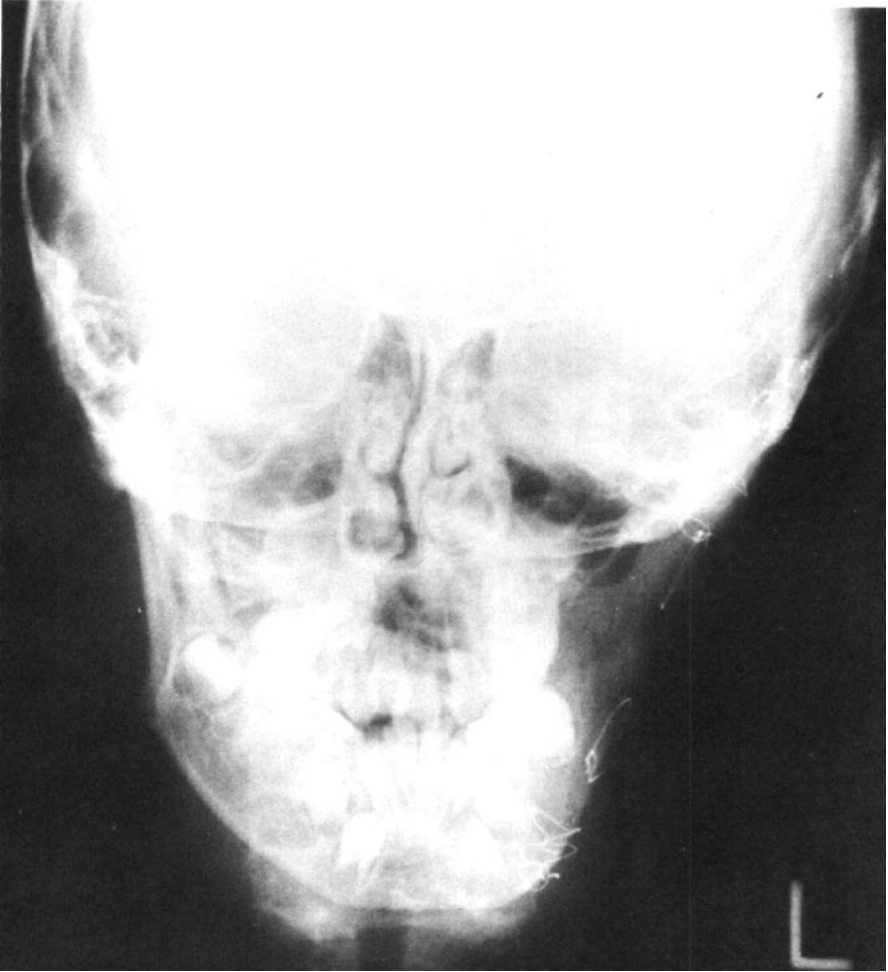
Postoperative postero-anterior radiograph
